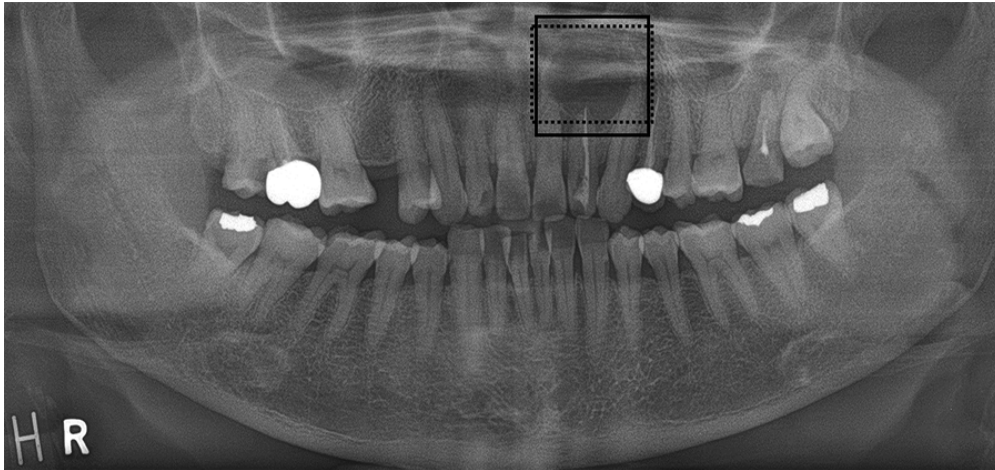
Detection of a periapical cyst. The solid line area is the disease area labeled by the radiologist and the dotted area is the predicted area.
